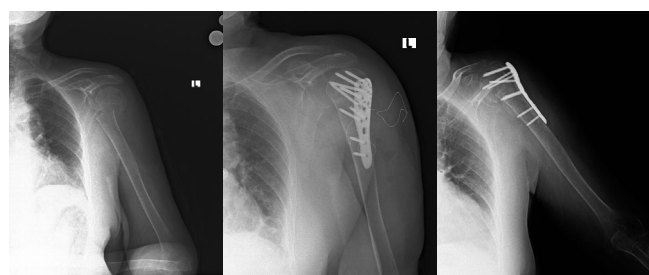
Plain radiograph of a 72 years old female patient with Neer Type 3 fracture (a). Immediate post-operative radiograph showing a satisfactory alignment and good fixation (b). Follow-up radiograph at the 8th month showing a varus collapse of the humeral head (c).
